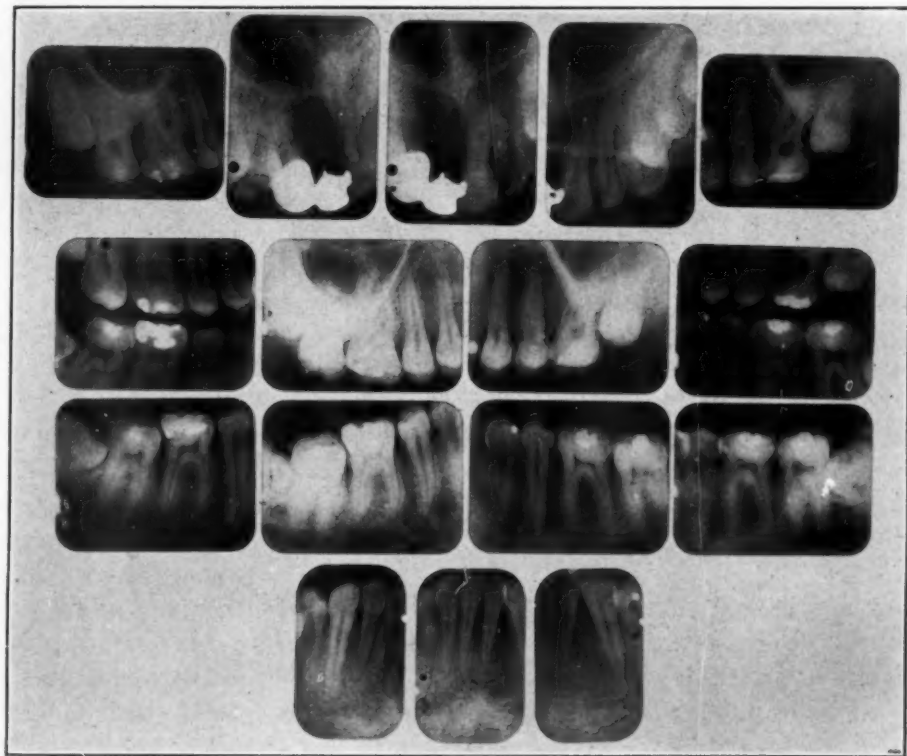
Radiographs of the completed case.
